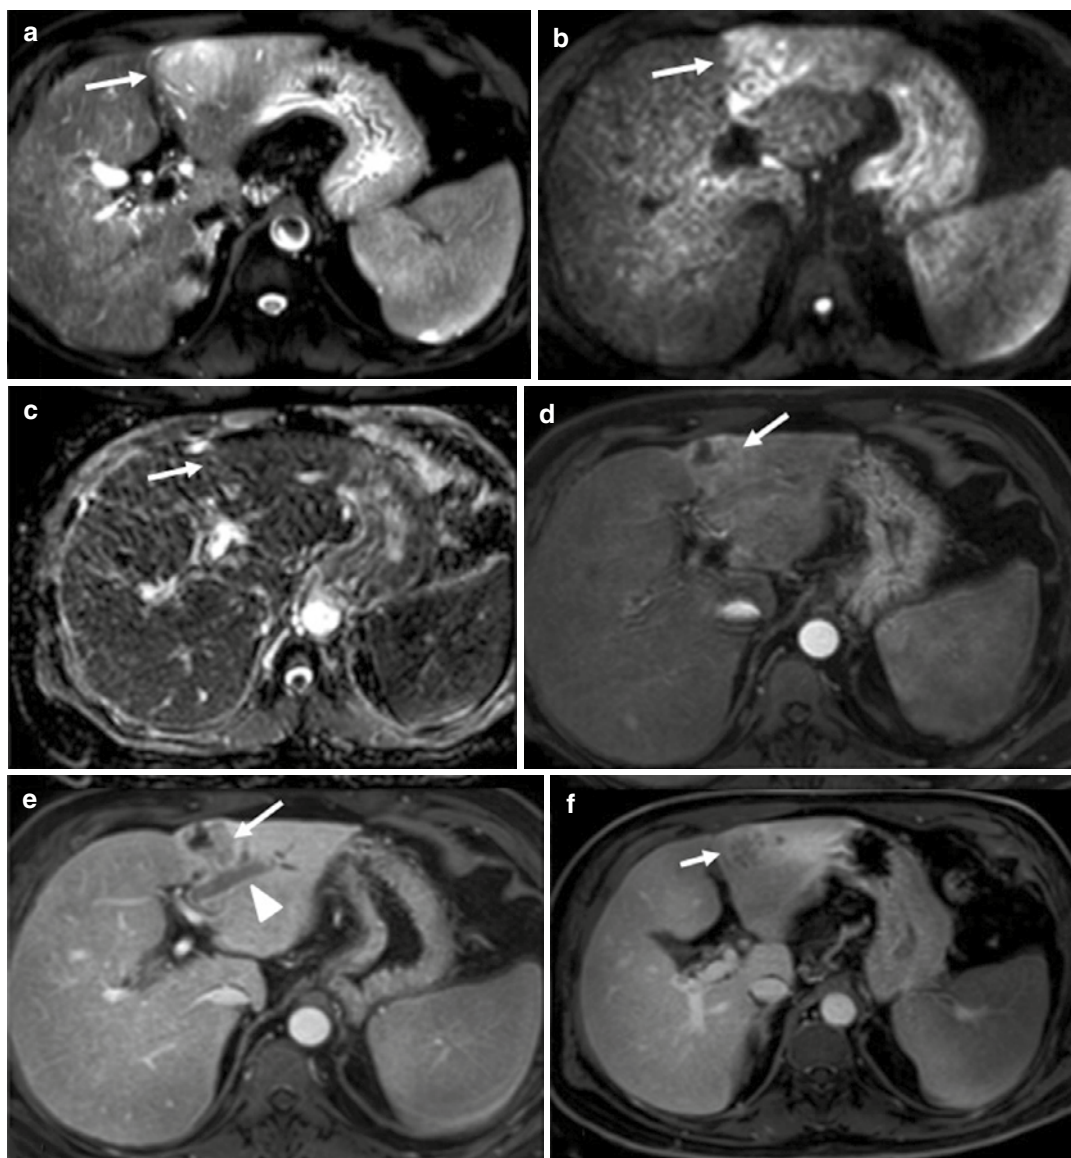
A 62-year-old male with hepatocholangiocarcinoma. (a) Axial T2-weighted MRI showed a well-defined, heterogeneous mass in the liver (arrow). (b, c) Axial high b-value (b=800) DWI (b) showed a hyperintense signal in the lesion with corresponding hypointensity on the ADC image (c). (d) Axial late arterial phase T1-weighted MRI showed heterogeneous enhancement
